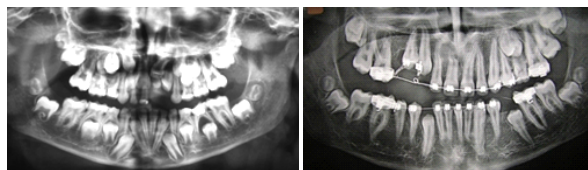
Initial and progress radiographies of case 3.
